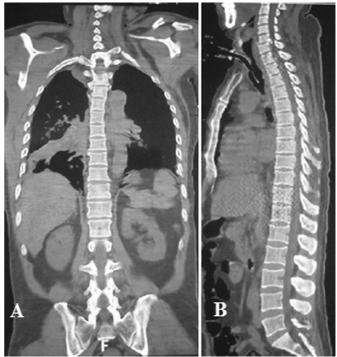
(A) Preoperative coronal CT of whole spine. (B) Preoperative sagittal CT of whole spine showing cervical distraction fracture and dislocation at $C_{6,7}$, minor anterior fracture of thoracic vertebrae at the T_{11} level and no fracture or dislocation at T_8 and T_9 .
